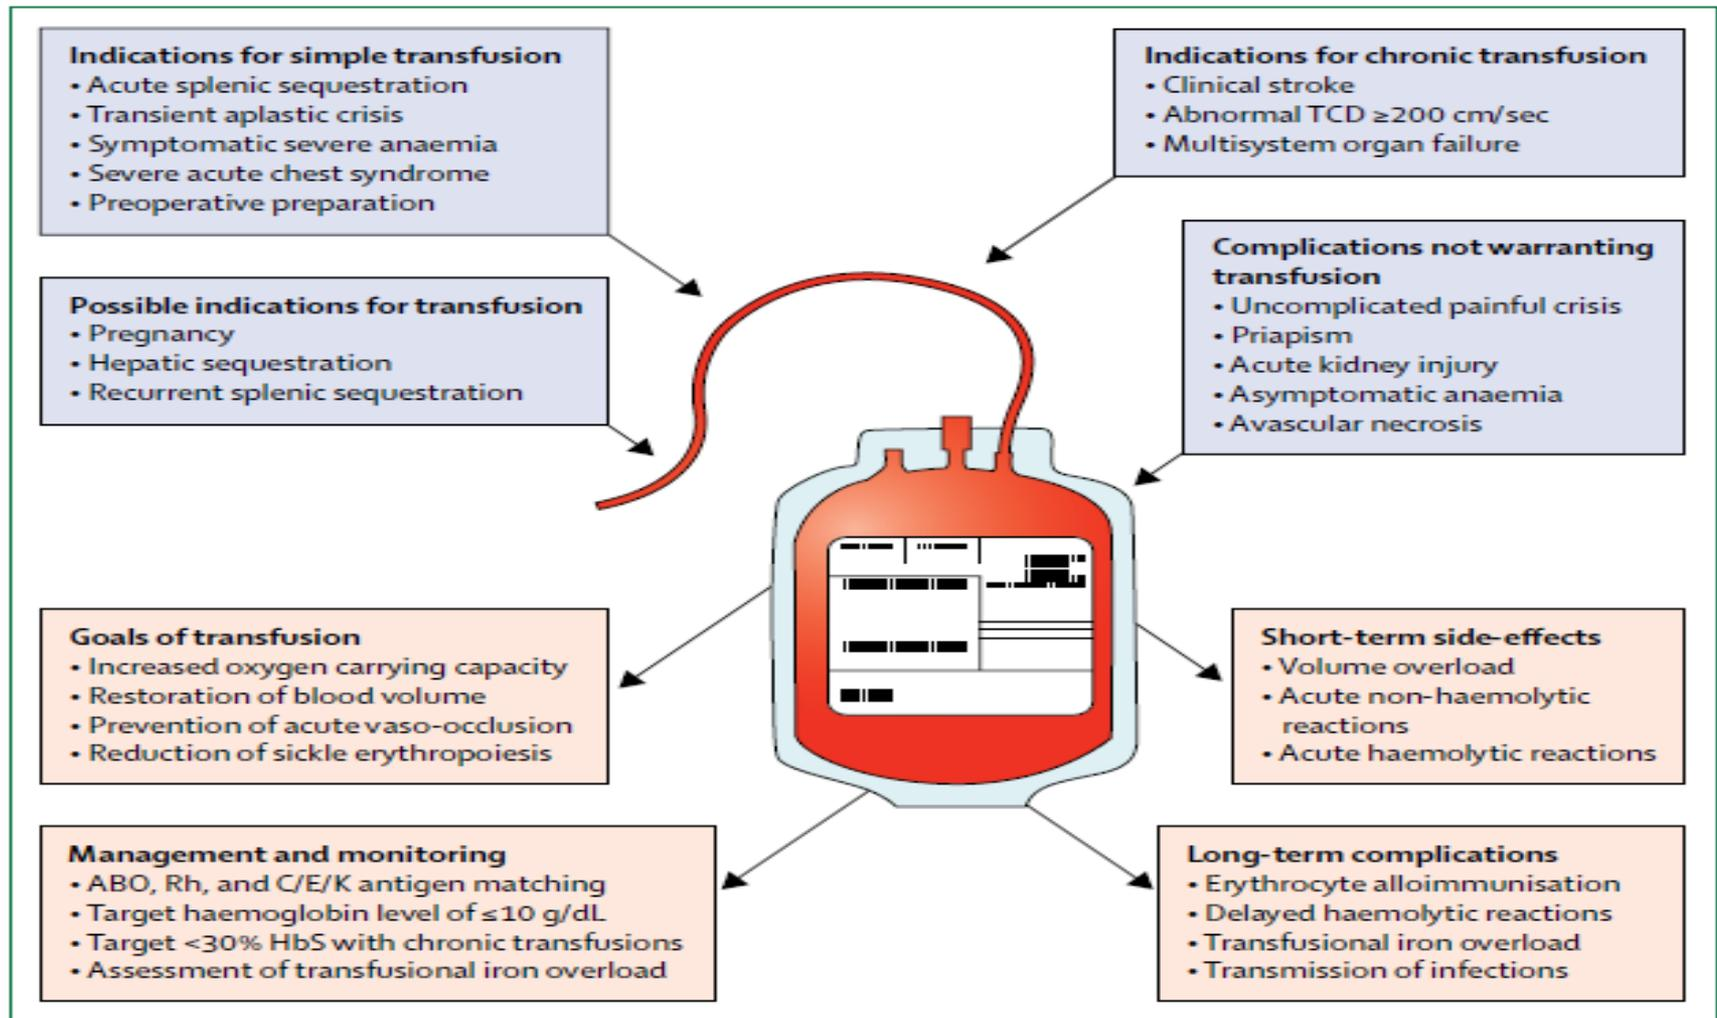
Clinical indications and goals that influence the decision to transfuse a patient with sickle cell disease Management and monitoring, and short-term and long-term complications are described. TCD=transcranial Doppler.
